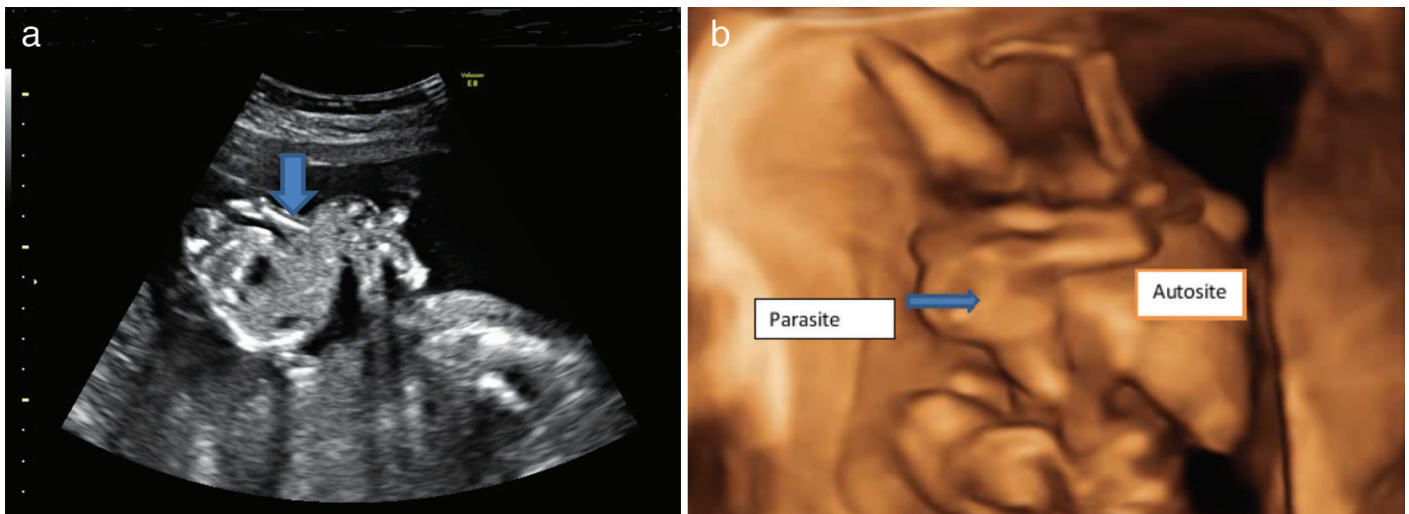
a) 2D ultrasound image showing transverse axial view of the upper abdomen of auto site with the stomach bubble. The arrow shows the origin of heteropagus with trunk, two lower limbs and malformed upper limbs, from the epigastric region of the autosite, b) 3D image of the epigastric heteropagus twin, parasitic twin arising from epigastric region of the autosite
